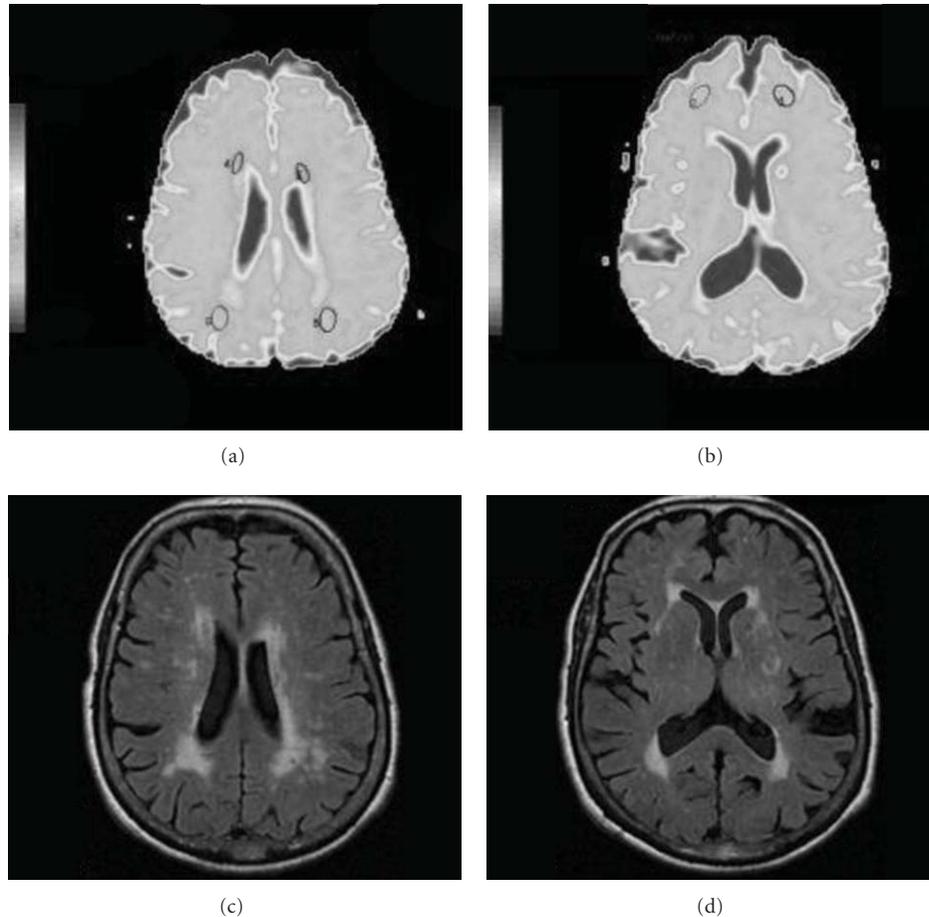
(a) and (b) ADC Map with representation of Regions of interest in Parieto-Occipital Normal Appearing White Matter (NAWM) and lesioned white matter (LWM) (a) and Frontal Normal Appearing White Matter (NAWM) (b). (c) and (d) Corresponding planes in FLAIR sequences.
